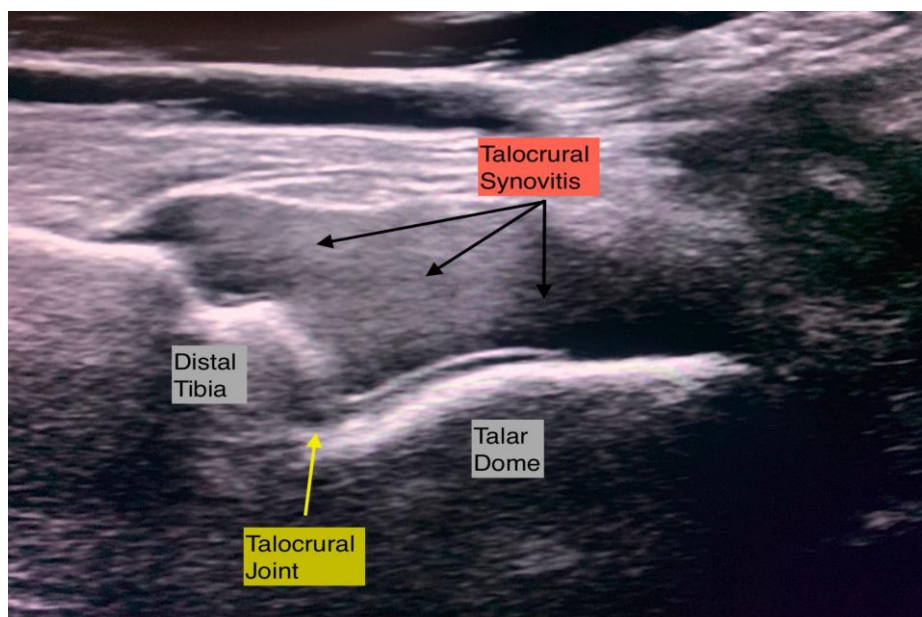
Long axis ultrasound view of the affected ankle joint
